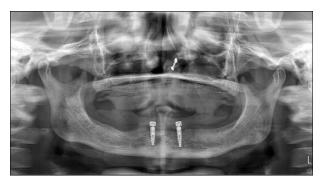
Post operative orthopantomogram with attachments
